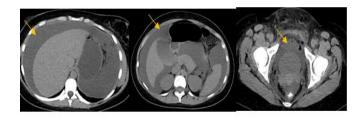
CT scan showing a significant amount of free fluid in the abdomen
